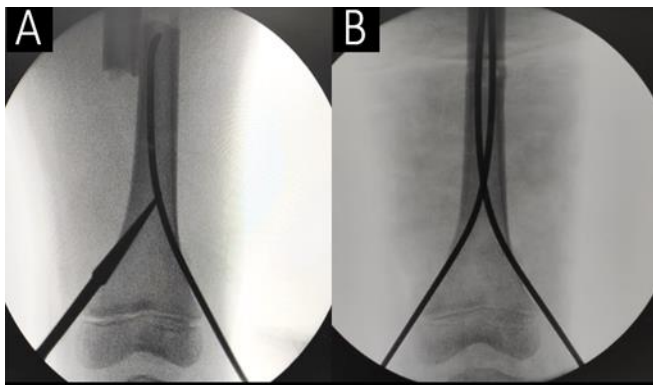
Intraoperative X-Ray images of left femur (Anteroposterior View). A: Pre-reduction image, B: Post reduction image
